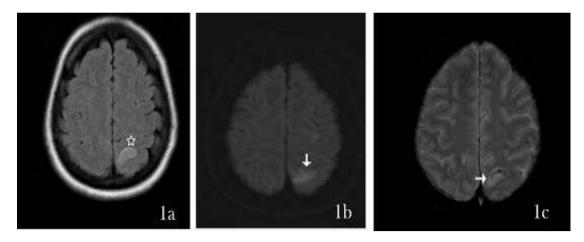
Axial sections of the brain shows an area of FLAIR hyper intensity involving the left parietal lobe (asterix) and restricted diffusion on DWI (down arrow) with foci of blooming on GRE (right arrow) suggestive of acute haemorrhagic infarct
